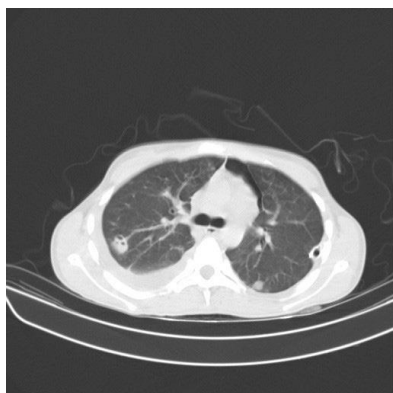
Spiral chest CT. Diffuse nodules often present with a thin-walled cavity in favor of septic emboli. Mild pneumothorax of the left lung is also noted.
